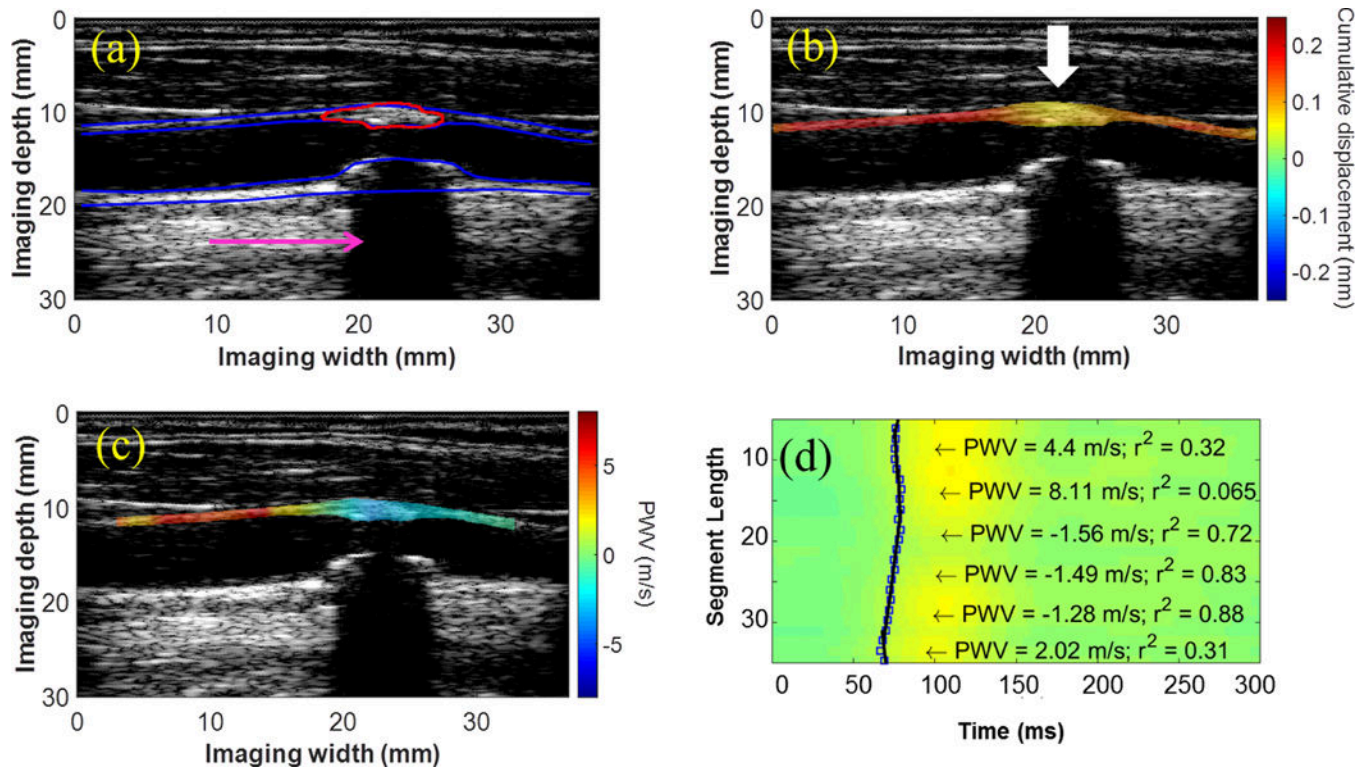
(a) B-mode image, (b) displacement map, and (c) PWV map from the right CCA of a 76-y.o. male obtained using a conventional ultrasound sequence. The pink arrow points to the acoustic shadow caused by the calcified posterior wall plaque, and the white arrows indicate regions of decreased displacement or pulse wave convergence. (d) Piecewise PWV measurements overlaid on the spatiotemporal map.
